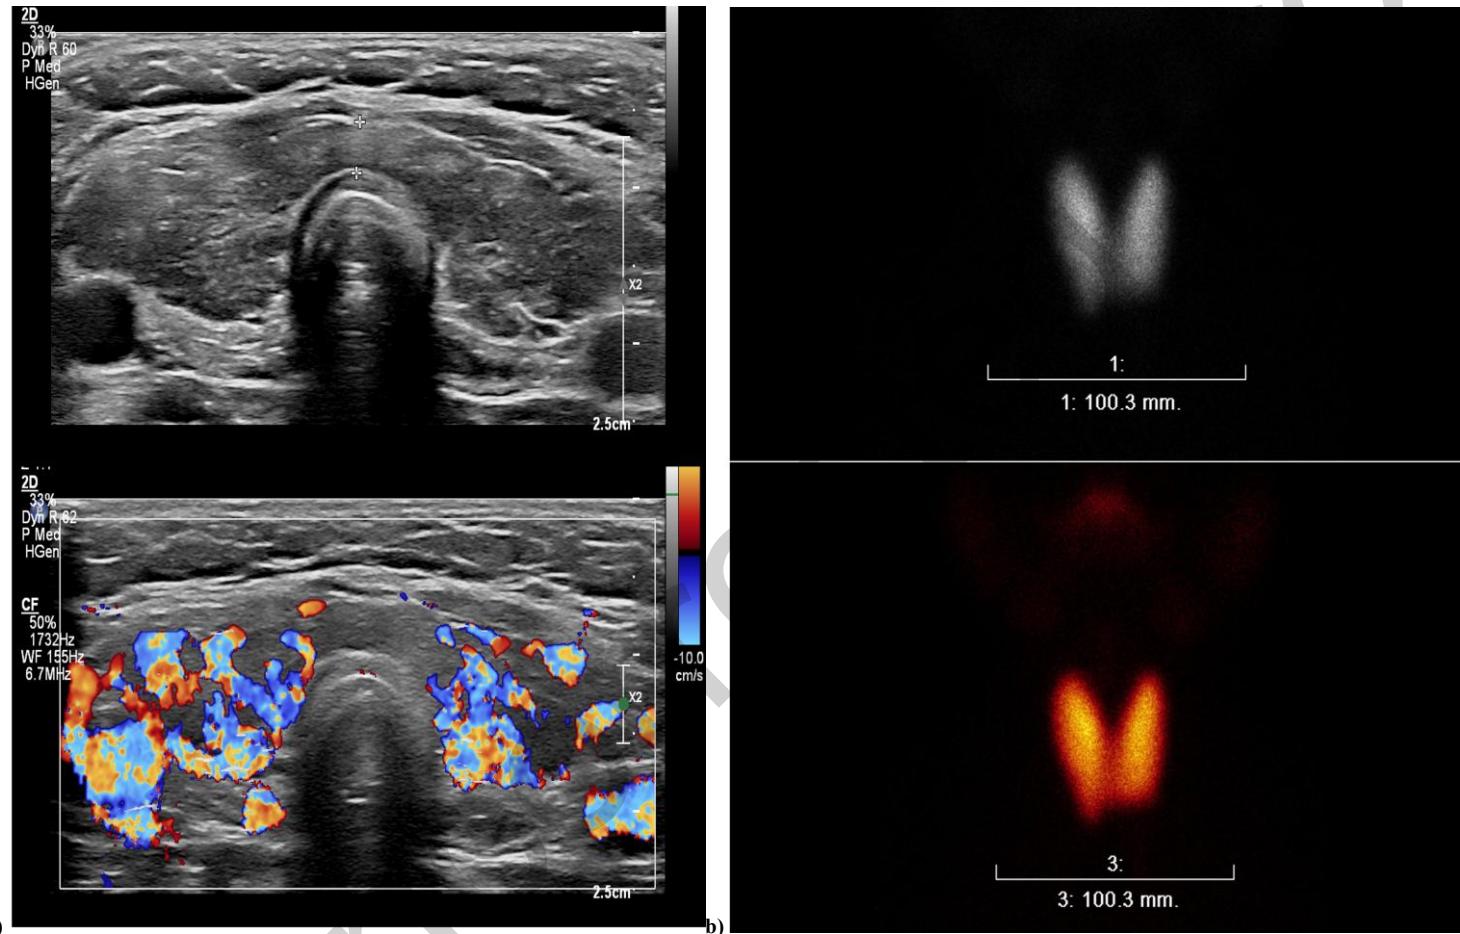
Thyroid ultrasonography and scintigraphy of the patient. a) Thyroid ultrasonography shows increased vascularity and coarse echogenicity. b) Thyroid scintigraphy demonstrates diffusely increased radionuclide uptake without evidence of focal lesions
